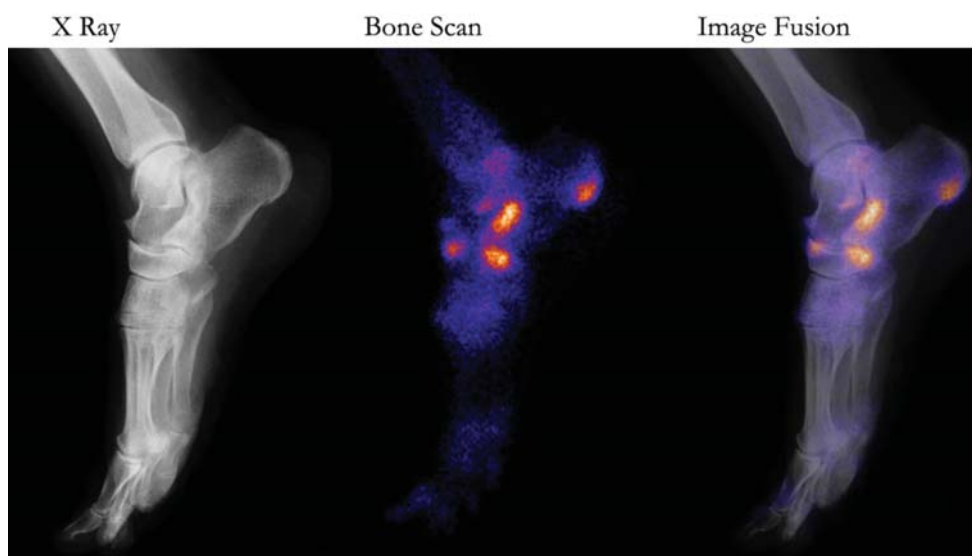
Anatomy (x-ray) and physiology (bone scan).
